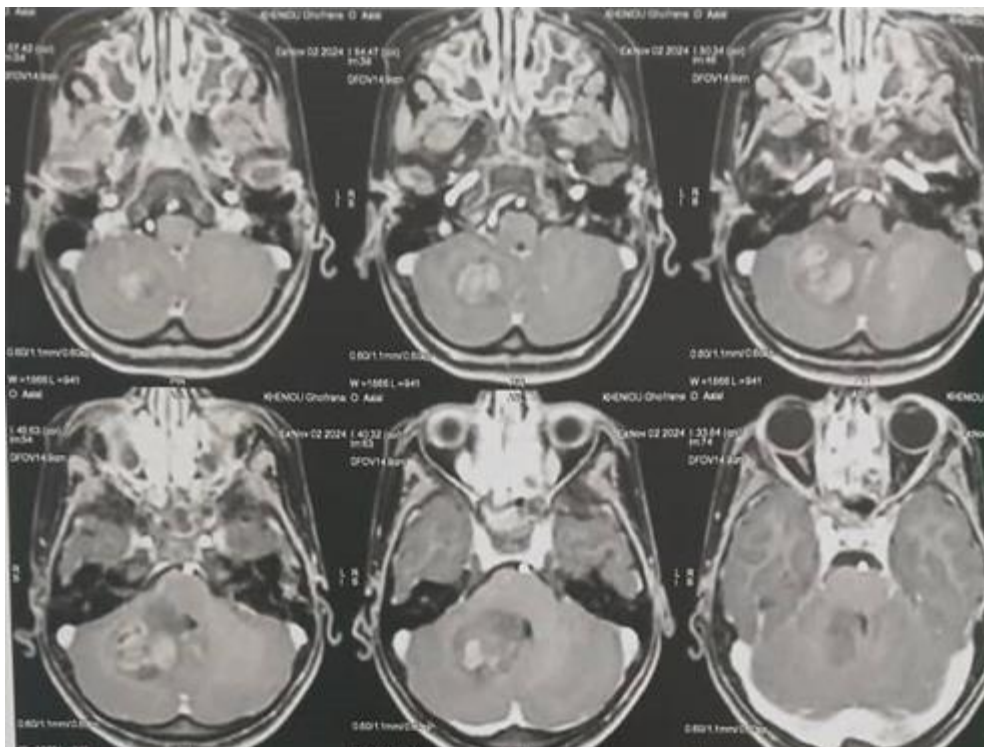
Pre operative magnetic resonance imaging showing a lesion in the right cerebellar hemisphere
